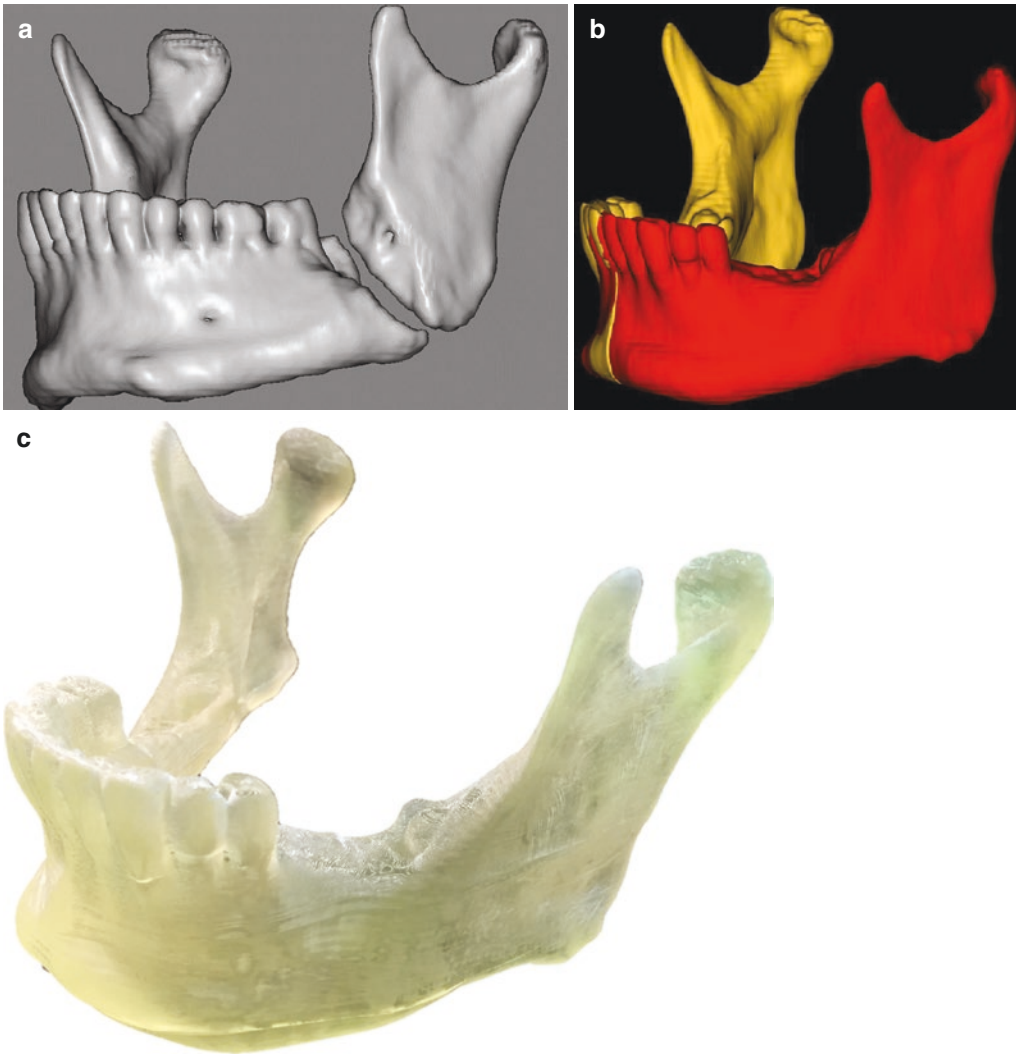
CBCT volumetric rendering (a) and segmented model of the mandible (b) of a patient with a left mandibular pathologic fracture associated with osteomyelitis after removal of a large dentigerous cyst. The left
